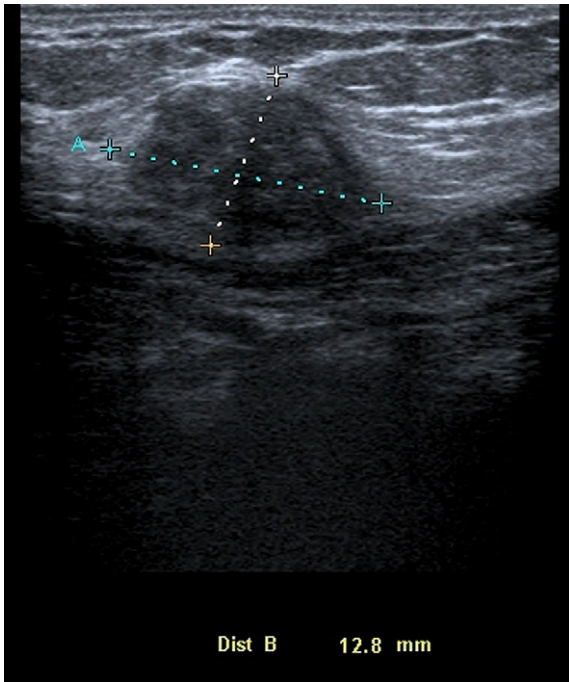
Implantation endometrioma seen in a caesarean section scar. The ultrasound appearances and clinical symptoms may differ during the different phases of menstrual cycle.
